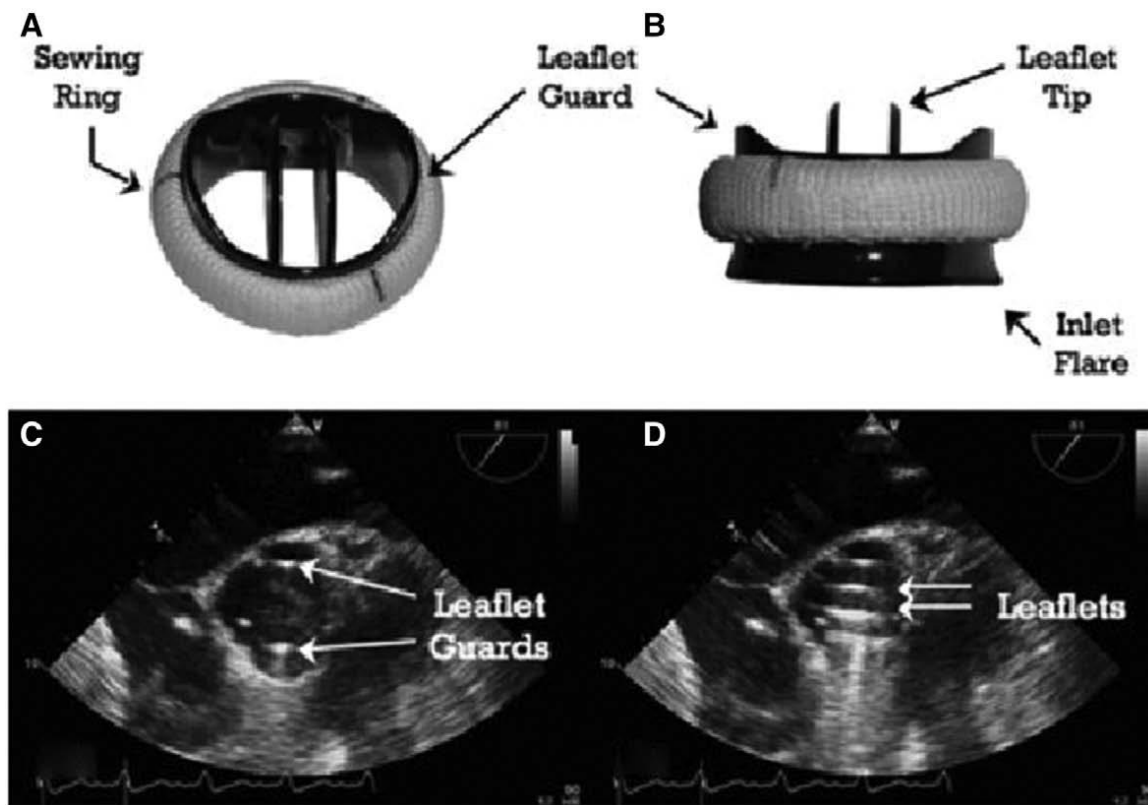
Echocardiographic features of the On-X valve. A, On-X valve short axis (SAX) in vitro; (B) On-X valve long axis (LAX) in vitro; (C) TEE image of the On-X valve closed in the midesophageal (ME) SAX view. D, TEE image of the On-X valve open in the ME SAX view. TEE indicates transesophageal echocardiogram.
